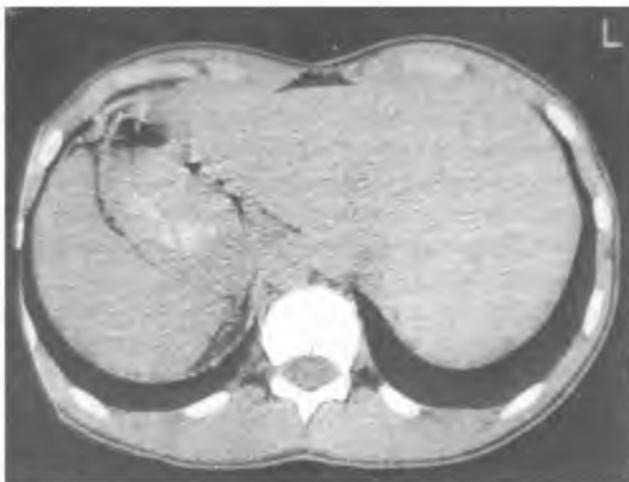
CT inverted position of abdominal organs
